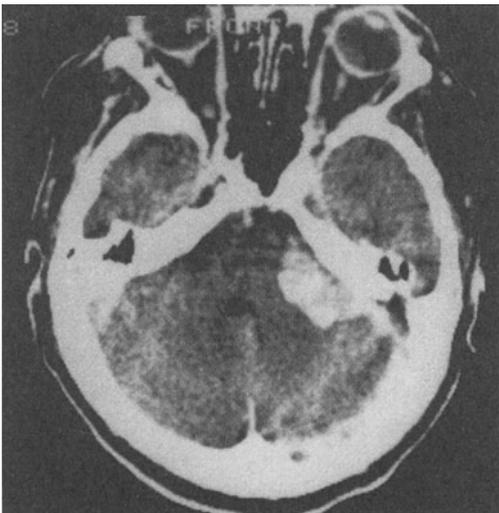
Computerized tomographic (CT) scan of the posterior fossa with contrast enhancement (C+). Cerebellar pontine angle tumor in a 65 year old female with a 17 year history of deafness in the left ear and a minor reduction of hearing in the right ear who had had additional findings of mild left peripheral facial weakness, ataxia of gait and dysmetria of left hand. The broad base along the left petrous bone suggested a meningioma. Courtesy of Dr. Tom Mullins.
